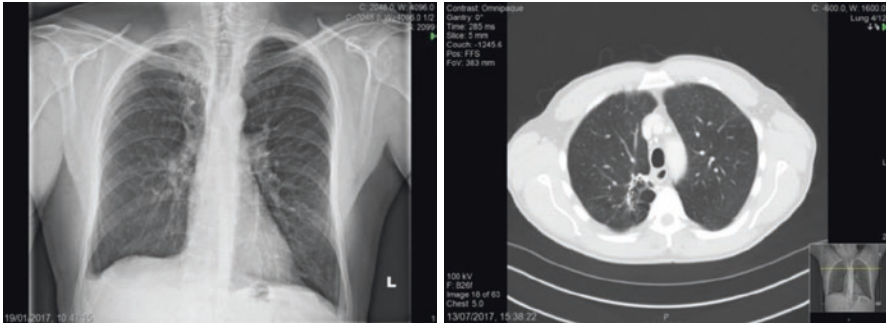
Chest X-ray and Computer Tomography scan of the 45-year-old man in Fig. 1 a year and 18 months into MDR-TB treatment, note the resolution of the abscess and scarring, mild improvement in right hemi thoracic volume
